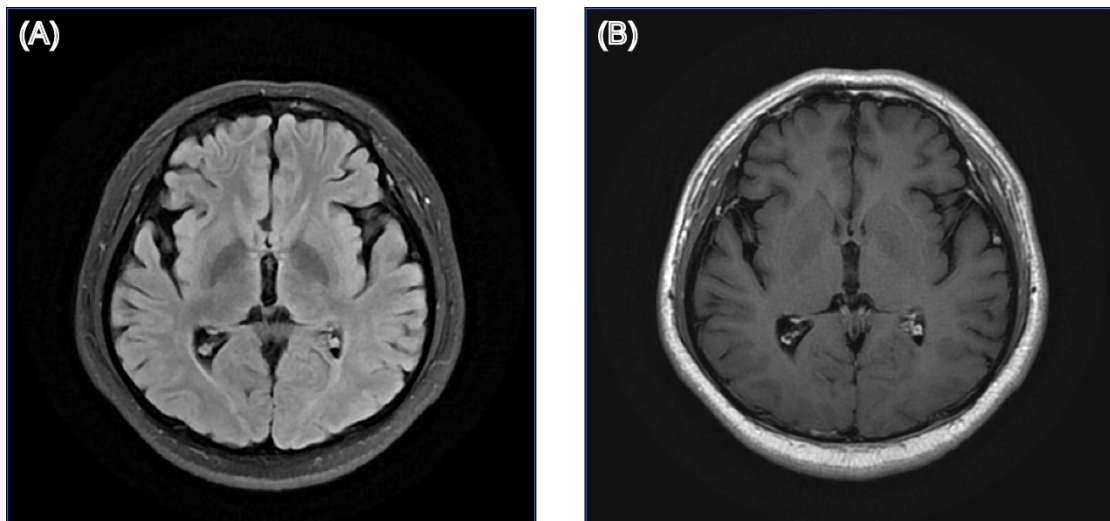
Structural brain MRI images of patient 11. (A) T2-weighted fluid-attenuated inversion recovery (T2-FLAIR) image; (B) Gadolinium-enhanced T1-weighted (Gd-T1w) image.
